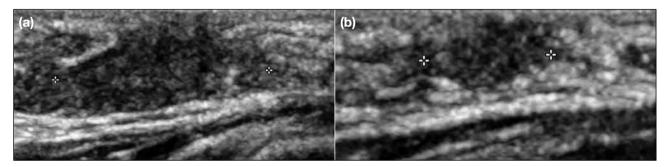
A 7-month-old female infant with palpable right breast mass. (a) Right breast. (b) Left breast. Ultrasound shows asymmetrical hypoechoic tissues in both retroareolar regions, more prominent on the right. There was spontaneous resolution at follow-up, consistent with physiological breast development.
